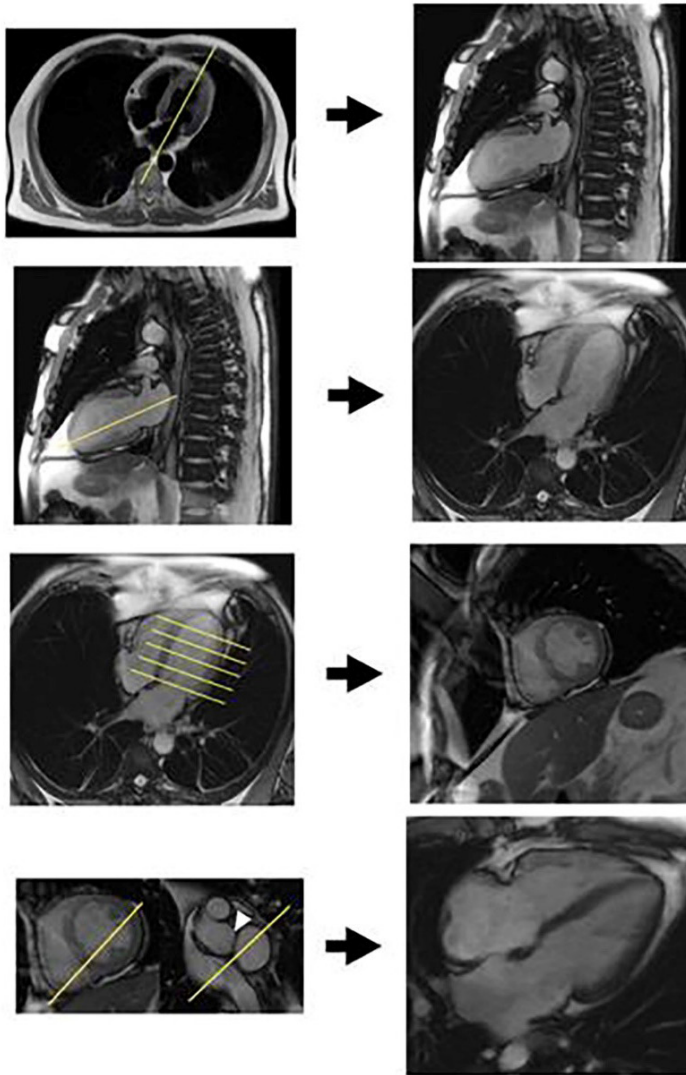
Cardiac view acquisition. Transaxial fast turbo spin echocardiography or half-Fourier single shot images (top left, first row). Single shot SSFP vertical long axis is planned in transaxial images, aligning through the apex and the centre of the mitral valve (second row). Horizontal long axis aligned through the apex and the centre of mitral valve in the previous vertical long axis (third row). Short axis stack is obtained using the horizontal long axis and aligning perpendicularly to the septum. Finally, a more accurate horizontal long axis SSFP cine is obtained aligning through the anterior papillary muscle and the right ventricular apex, avoiding the aortic root (white arrowhead in the left lower bottom panel).
